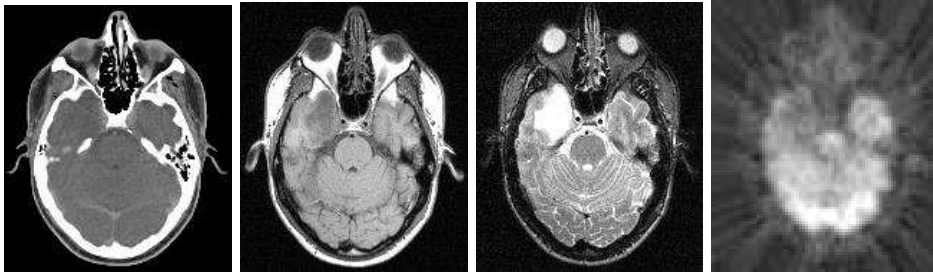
Slices from four modality images of a same patient. From left to right: CT image, T1 MRI, T2 MRI, and SPECT Image.
